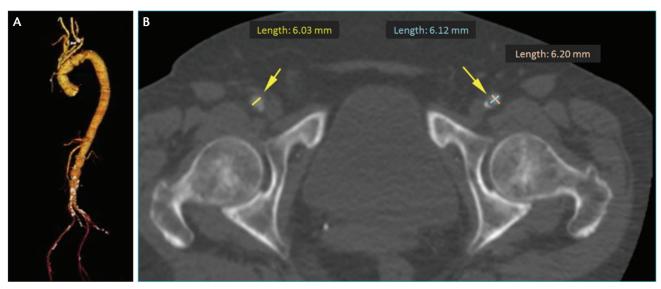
Reconstruction of the aorta as well as the iliofemeral vessels (A). CT scan highlighting access vessel size (B).
